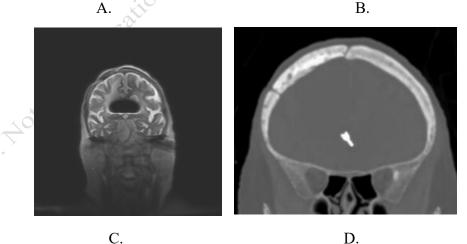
Examples of pronounced susceptibility artifact on 1.5T localizer images associated with ferromagnetic intracranial aneurysm clip (A, B, C). The ferromagnetic clip is seen on the CT images (D). In this case, the patient was removed safely from the scanner using slow table speed, the table detached and wheeled out of the room slowly without the patient sitting up.
